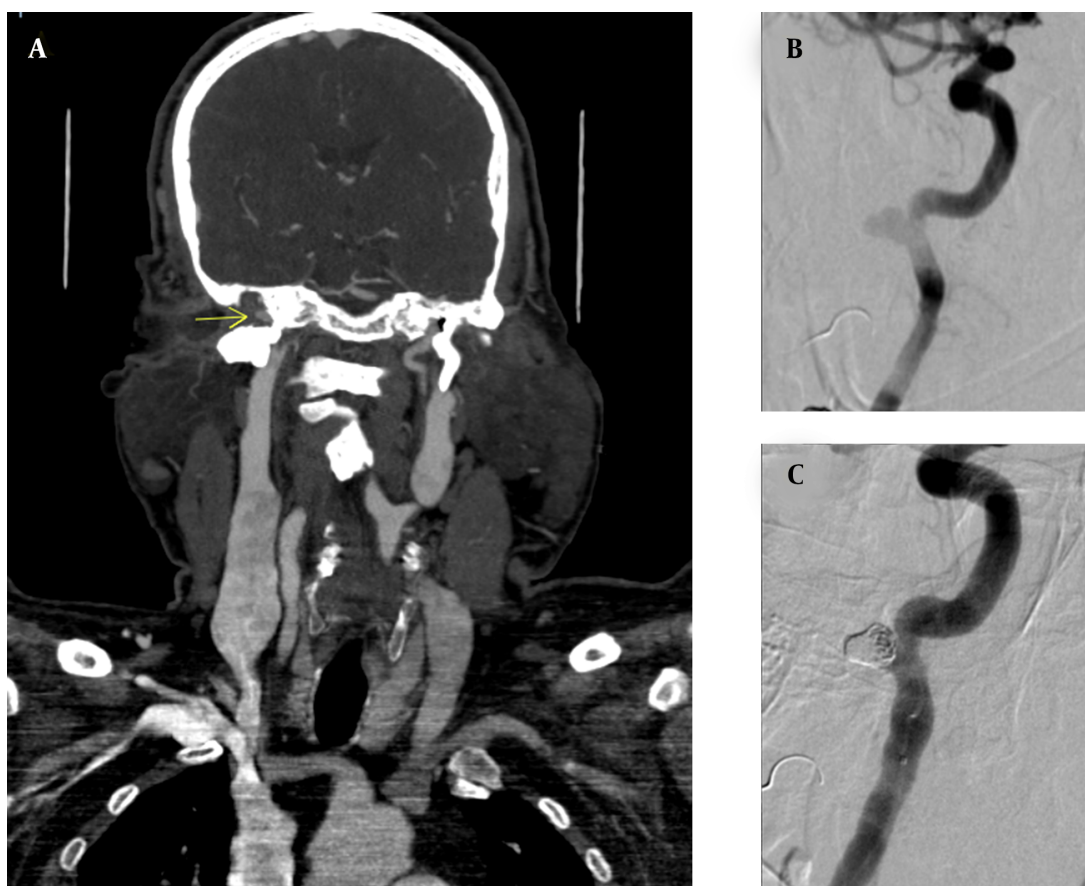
Pre- and post-treatment images of pseudoaneurysm. (A) CT angiography of the head and neck, indicating a petrous internal carotid artery pseudoaneurysm; (B) Conventional angiography, indicating a pseudoaneurysm; (C) Conventional angiography indicating the obliteration of pseudoaneurysm.
